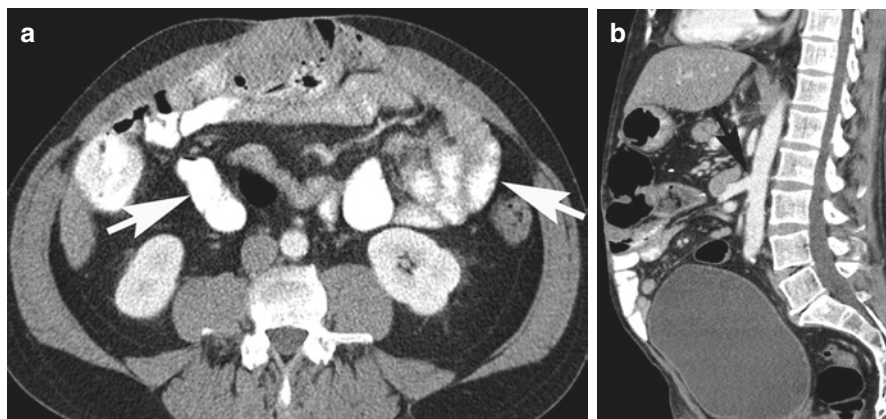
Normal isolated intestinal transplant in a 48-year-old man who developed short bowel syndrome from multiple small bowel resections for Crohn disease. (a) Intravenous and oral contrast-enhanced CT scan shows the transplanted small bowel is normal in caliber with normal wall thickness and fold thickness (arrows). (b) Arterial inflow is from an infrarenal aortic to aortic anastomosis (arrow). The donor SMV to recipient SMV anastomosis is not shown
